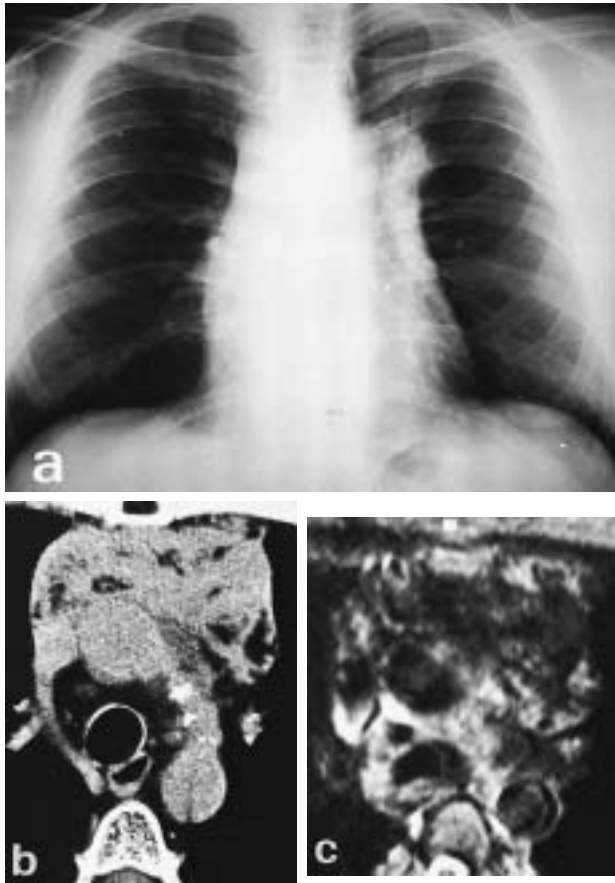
Residual mass in malignant non-Hodgkin's lymphoma. a) Chest radiograph; and b) computed tomography (CT) show extended soft tissue in the anterior mediastinum after chemotherapy and radiation of malignant B-cell lymphoma. Differentiation of fibrosis and tumour relapse is not possible. c) Corresponding (to CT) transverse T2-weighted magnetic resonance (MR) image displays fibrosis nearly signal-void, interspersed fat with higher signal intensity (SI) corresponds with low attenuation values in CT and high SI in T1-weighted MR (not shown). High SI is due to flow phenomena in the anterior azygos vein and fluid in the upper retroaortic pericardial recess.
